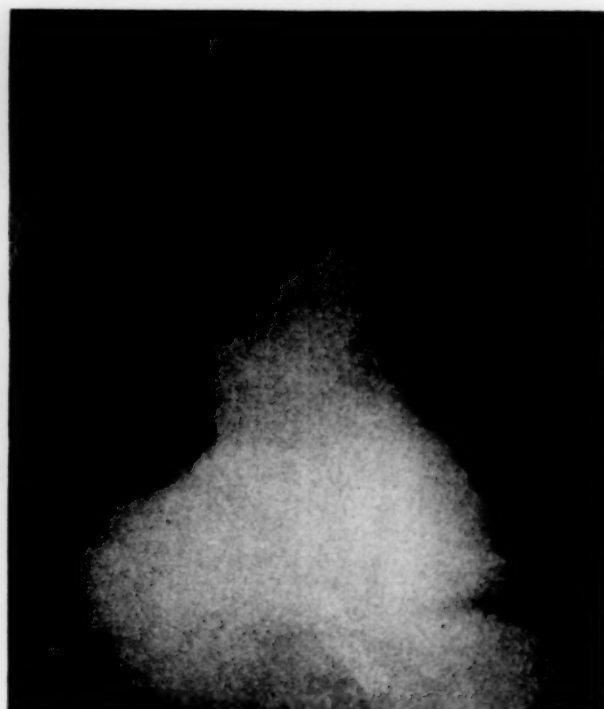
X-ray taken at conclusion of radiation therapy, Case v.
